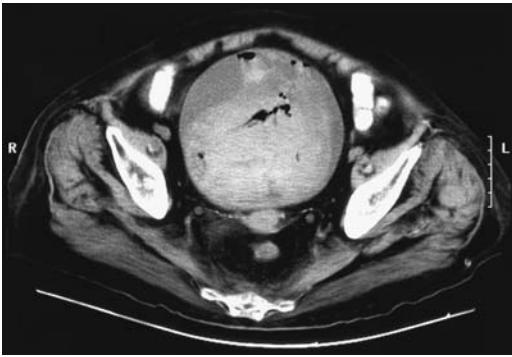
Hemorrhagic cystitis due to Cytoxan therapy. Computed tomography reveals a thick-walled bladder containing blood clots, debris, and gas. (Courtesy of Patrick Fultz, M.D., University of Rochester.)
